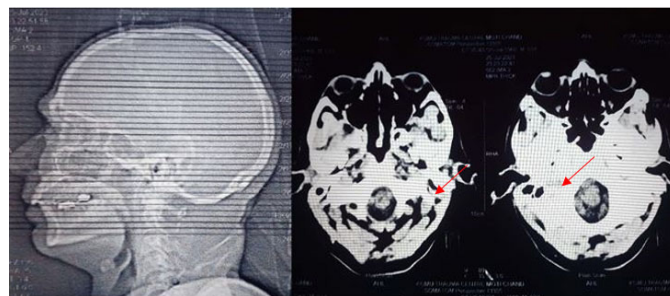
Axial CT brain images showing hypodense areas in the posterior circulation suggestive of infarction (highlighted by red arrows).
